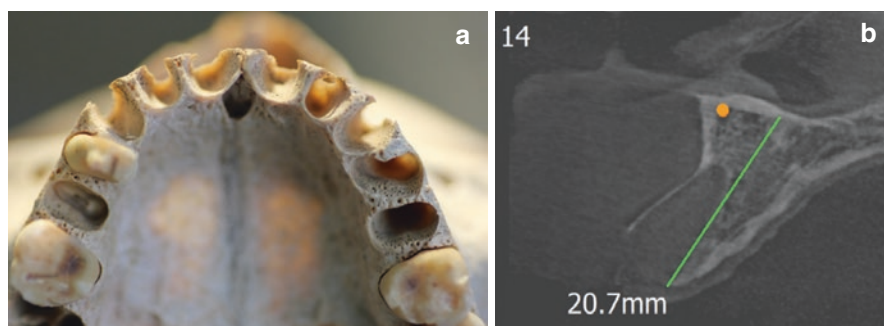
(a) The alveolar bone proper can be visualized in the images. It is delicately thin and is easily destroyed by faulty extraction techniques. The marrow spaces appear as perforations giving the name cribriform plate. (b) The cone beam computed tomography (CBCT) section of a recently extracted tooth depicts the thinness of the labial plate
